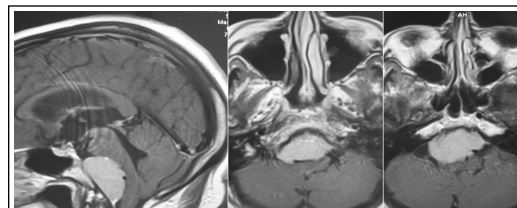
MRI T1. Low clival meningioma (Anterior lateral localization).
